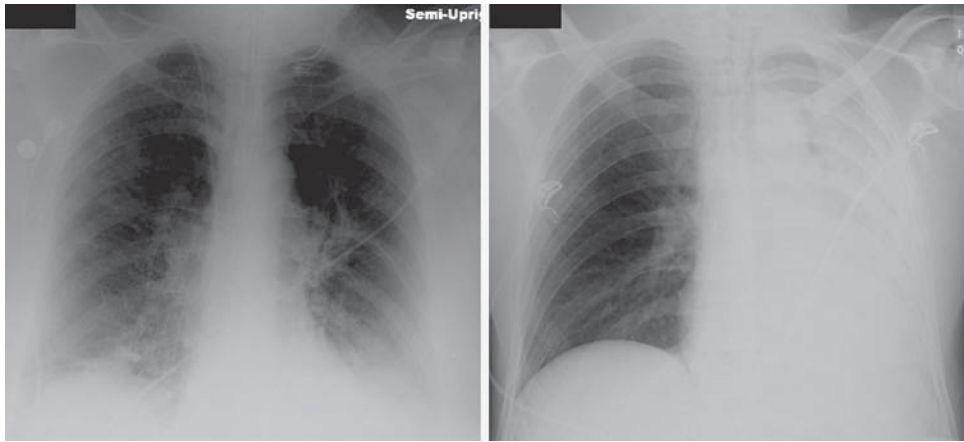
Postoperative atelectasis. *Left:* Portable anteroposterior chest radiograph showing bibasilar subsegmental atelectasis following hemicolectomy. *Right:* Atelectasis of the entire right lung caused by mucus plugging following drainage of submandibular and pterygomandibular space abscesses.
